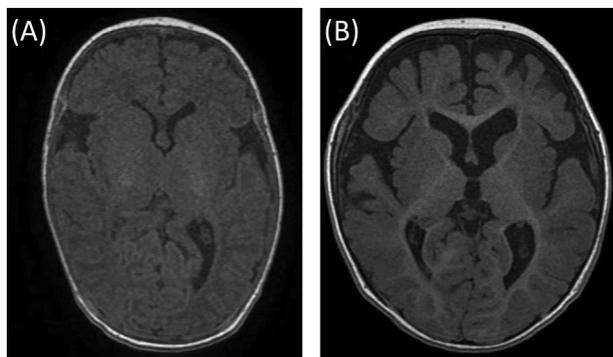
T1-weighted MRI at 45 days (A) and 11 months (B) after birth revealed no abnormal findings and progressive cerebral atrophy, respectively.
